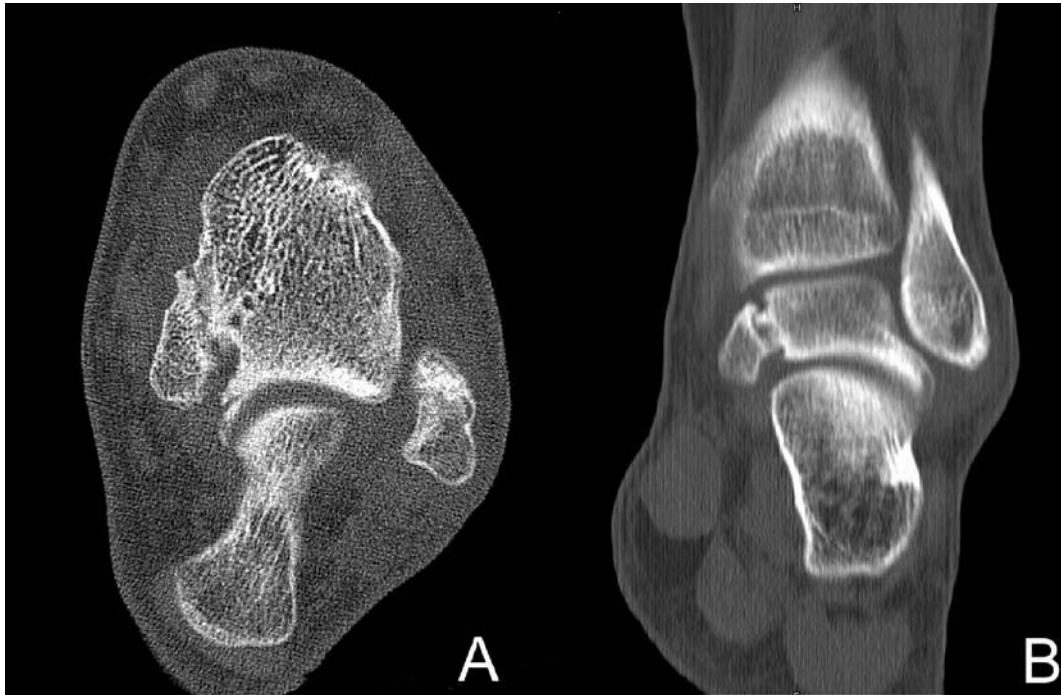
Multislice computed tomography showing a non-union fracture of the posteromedial process of the talus in axial view (A) and coronal view with visible interposition of smaller fragments (B).
